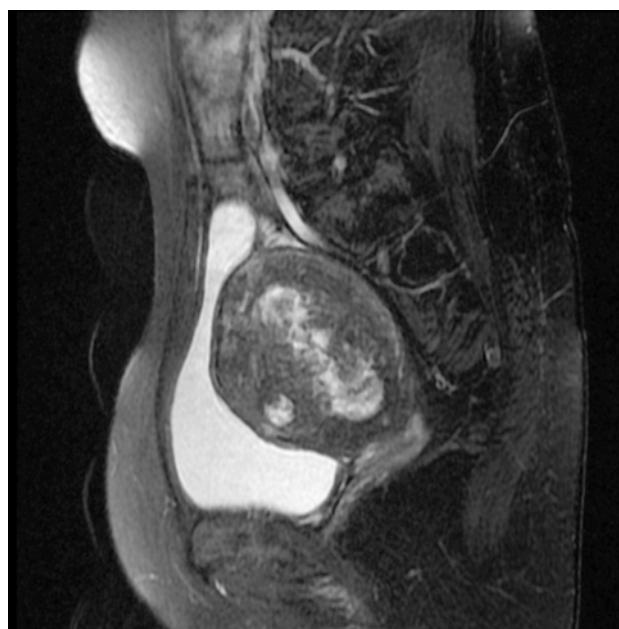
MRI of preoperative axial and T2-weighted images. The submucosal tumor was identified in the uterine body. The tumor size was 7.0 x 6.4 x 4.3 cm.
